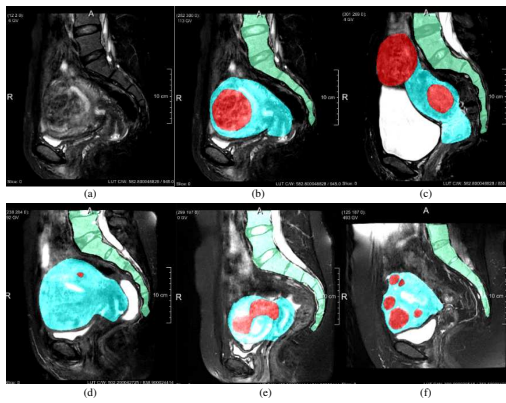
MR images of uterus regions in different patients. Red denotes the fibroids, blue the uterus, and green the spine. (a) Patient 71 slice14 of raw MR image. (b-f) The labeled images of Patient 71 slice14, Patient 84 slice14, Patient 93 slice12, Patient 26 slice12, Patient 8 slice13. We can observe 1) large shape and size variations among individuals; 2) a low contrast between adjacent organs and tissues; 3) highly variable uterine fibroids numbers and shapes.
